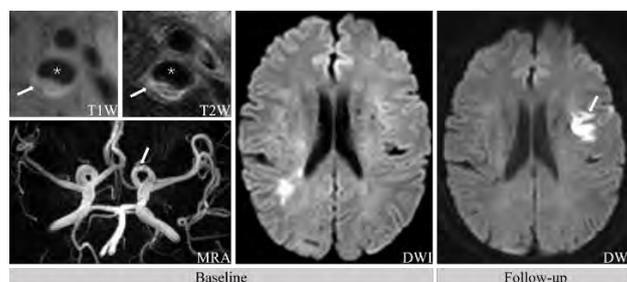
An example for a 63 years old male patient who had atherosclerotic plaque in the extracranial internal carotid artery (white arrows on T1W and T2W, respectively) and intracranial artery stenosis (white arrow on MRA). after a year of follow-up, a new acute infarction was detected in the left hemisphere on followed-up DWI images (white arrow).
